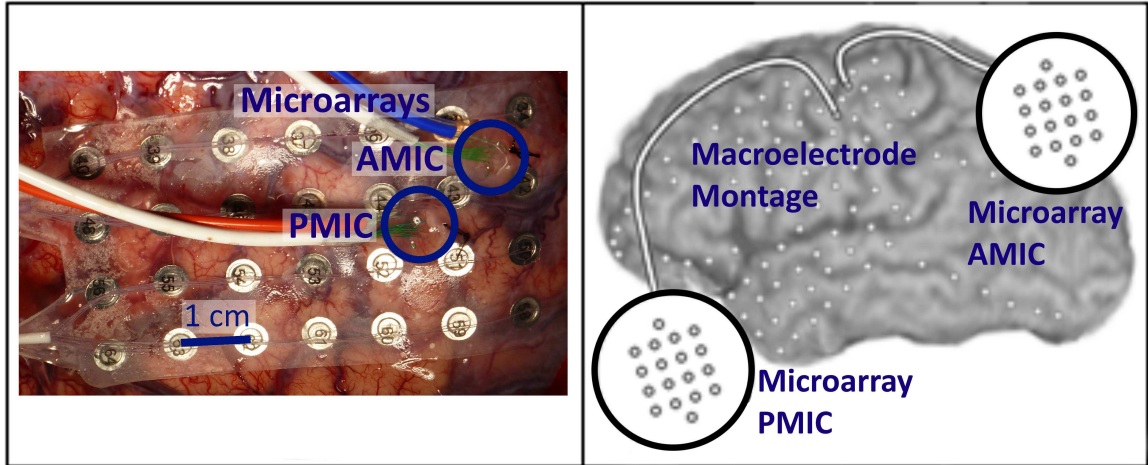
Macroelectrode and microelectrode ECoG array placement. Two microelectrode arrays were inserted within the macroelectrode grid. Additional recordings were obtained from macroelectrode strips placed on superficial layers of cortex. Intraoperative photo (left), 3D MRI reconstruction of electrode sites (right).
